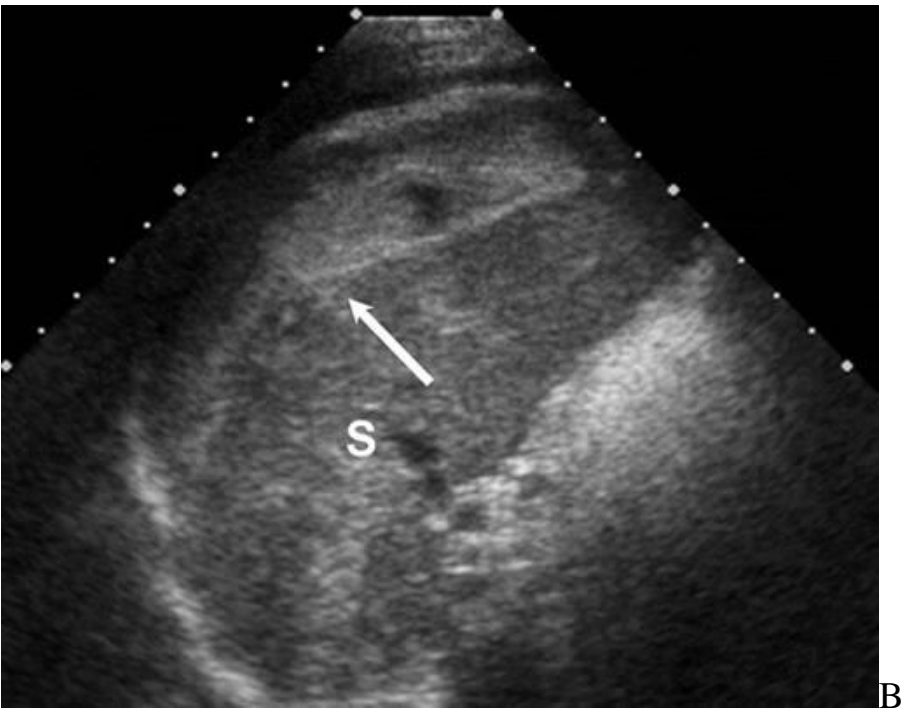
Abdominal gunshot wound. Splenic rupture, hemoperitoneum (arrow). A – CT scan; B – ultrasound view.
